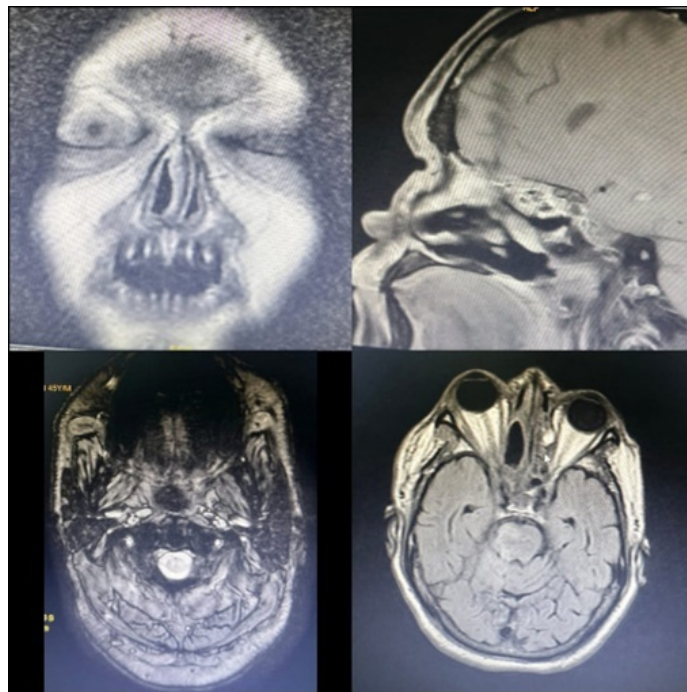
MRI brain in T1,T2W1 view suggesting Subacute infarcts in the right cerebellar hemisphere, anterior cerebellum, peduncles, midbrain, and pons, diffusion restriction and enhancement of the right trigeminal nerve (Meckel's cave to foramen ovale), pachymeningeal enhancement along medial temporal dura, chronic small vessel ischemic changes in periventricular and fronto-parietal regions, extensive mucosal thickening in paranasal sinuses with extension to infratemporal and pterygopalatine fossae, right orbital apex syndrome with optic nerve and peri-orbital involvement, post-surgical changes from prior sinus surgeries like maxillectomy, ethmoidectomy, sphenoidotomy and right middle turbinectomy.
